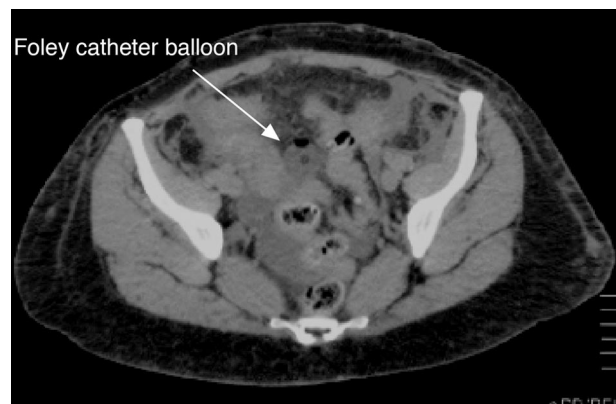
Computed tomographic scan of the abdomen/pelvis showing an intraperitoneal urinary catheter balloon with moderate ascites, consistent with an intraperitoneal bladder injury.
